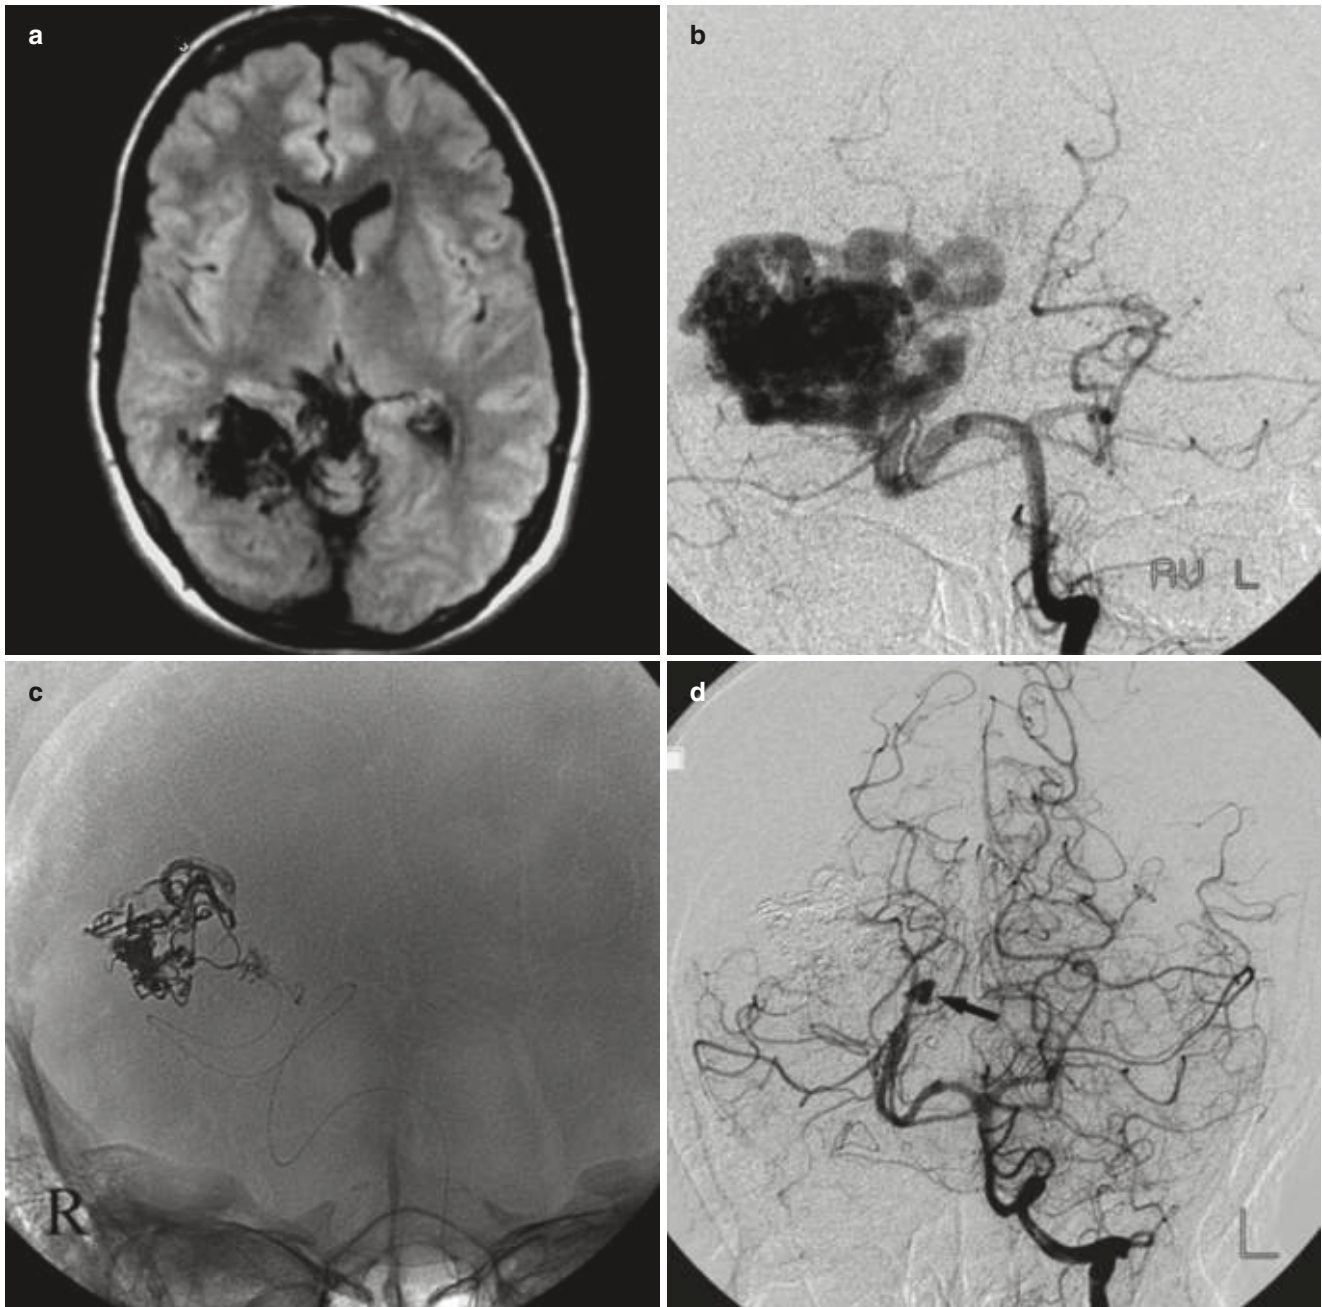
Arteriovenous malformation (AVM). A 30-year-old woman with acute homonymous hemianopia to the left. (a) T2-weighted (T2w) axial MRI showing the nidus of the AVM in the right occipital lobe. (b) DSA of the left vertebral artery in frontal view. Note the enlarged diameter of the right posterior cerebral artery in comparison to the left, due to high arteriovenous shunt volume. (c) Corresponding unsubtracted
